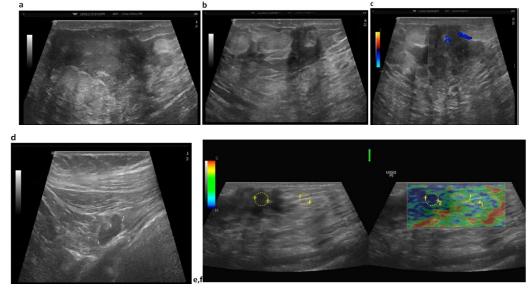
(a) (b) Left breast showed diffuse edema with large illdefinedhypoechoicretroareolar lesion with echogenic fat lobules and intercommunicating collections associated with diffuse mild skin thickening measuring 6mm. (c) On color Doppler shows increase vascularity. (d) Left axillary lymph nodes are seen enlarged with one showing cortical thickening reaching 5mm with relatively effaced fatty hilum. (e) Left breast quantitative elastography SR 4.7. (f) Left breast qualitative elastographyEscore 4.
